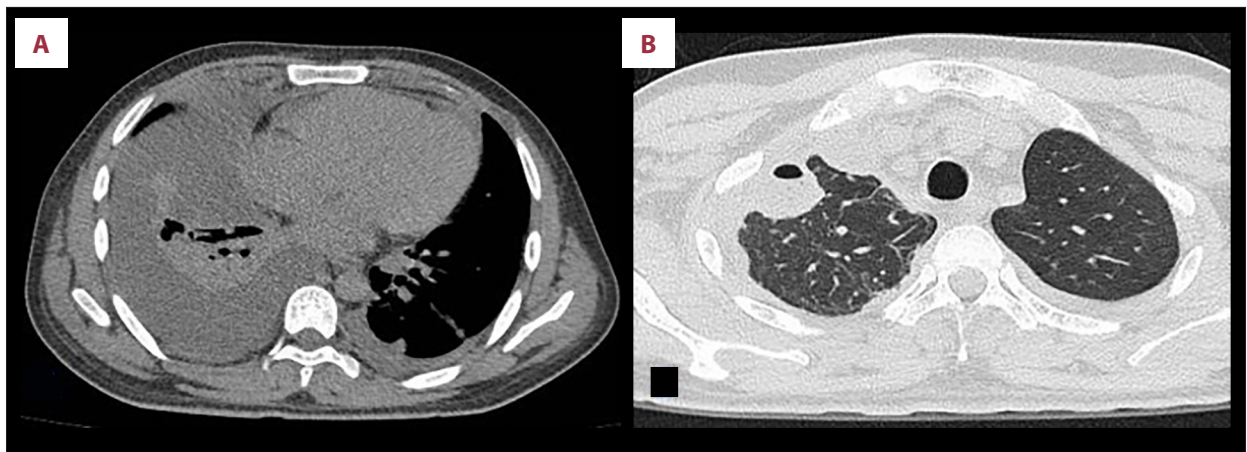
Non-contrast chest computed tomography demonstrates (A) a right-sided pleural effusion with high-attenuation fluid and loculated collections extending toward the apical and basal regions, and (B) a rounded pleural-based fluid collection in the right pulmonary apex containing internal gas bubbles, measuring 68 × 31 mm, with associated pleural thickening, consistent with a complex pleuropulmonary suppurative process.
